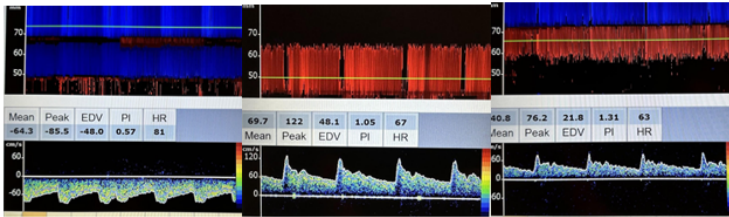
Side-by-side flow patterns and velocities of the anterior cerebral artery, middle cerebral artery, and posterior cerebral artery on transcranial Doppler.
